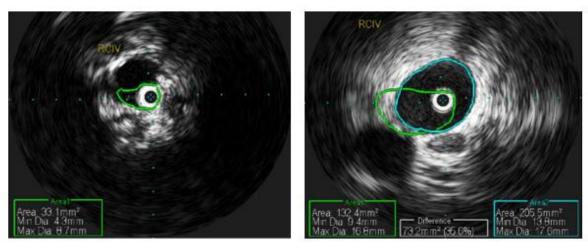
Figure II A and B: intravascular ultrasound of right common iliac vien (pre and post laser atherectomy and valvoplasty)
